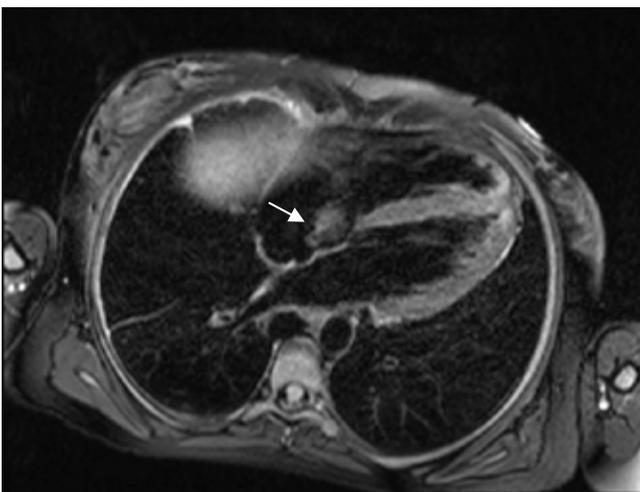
T-2 weighted cardiac magnetic resonance image showing an iso to hyperintense mass attached to the interatrial septum at the site of fossa ovalis, obstructing the tricuspid valve (arrow)
